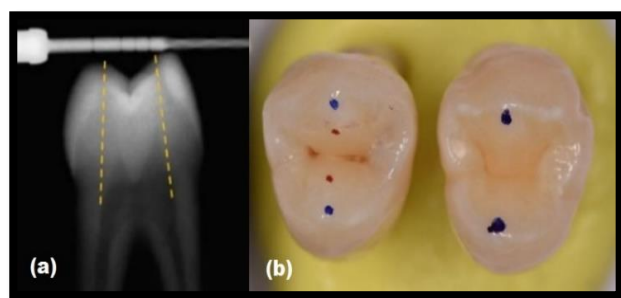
Access cavity dimension planning. (a) Lateral periapical x-ray shows an interrupted yellow line representing the straight-line endodontic access. (b) Occlusal surface with blue and red dots represents the traditional and conservative endodontic access cavity extensions, respectively
